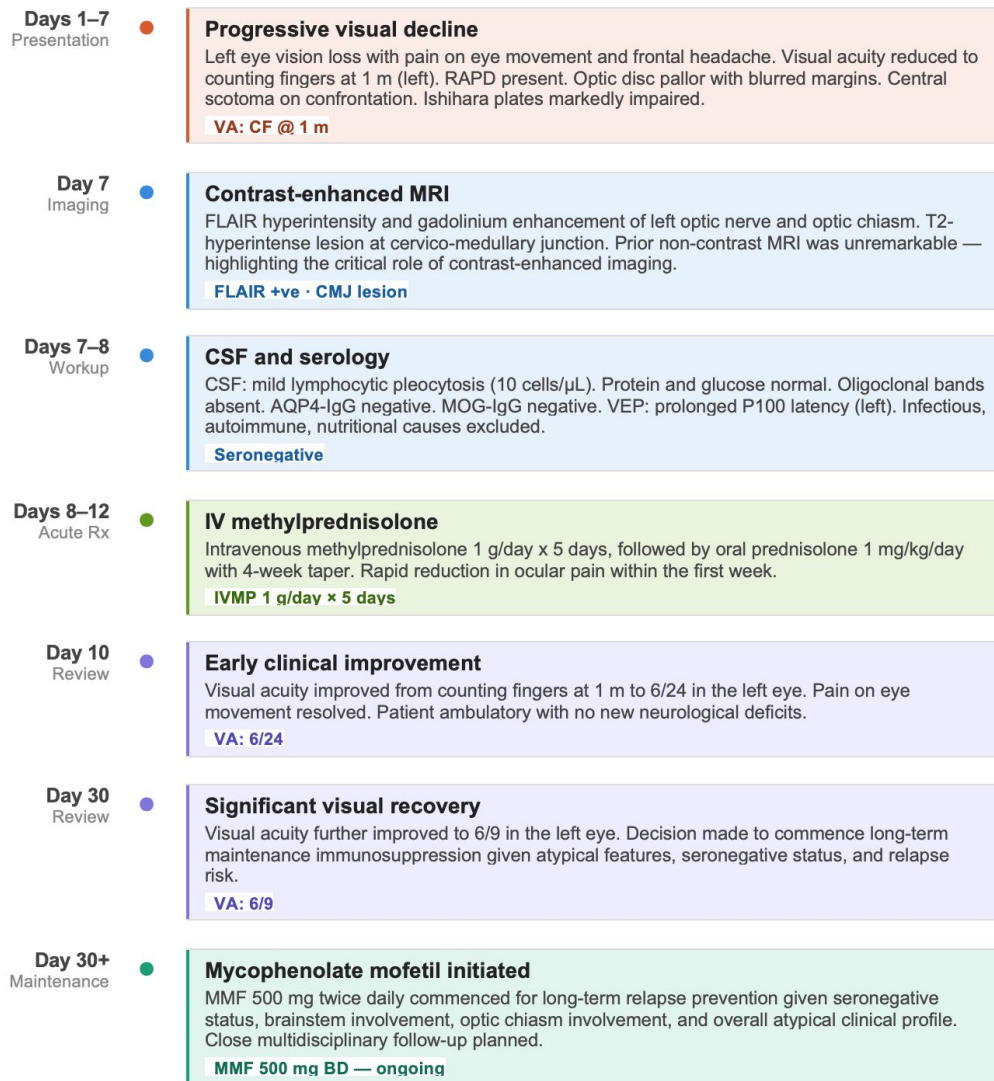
Clinical timeline — atypical seronegative optic neuritis with brainstem demyelination. Chronological case milestones from symptom onset through maintenance therapy. VA: visual acuity; RAPD: relative afferent pupillary defect; FLAIR: fluid-attenuated inversion recovery; CMJ: cervico-medullary junction; CSF: cerebrospinal fluid; AQP4-IgG: aquaporin-4 immunoglobulin G; MOG-IgG: myelin oligodendrocyte glycoprotein immunoglobulin G; VEP: visual evoked potentials; CF: counting fingers; IVMP: intravenous methylprednisolone; MMF: mycophenolate mofetil; BD: twice daily.
